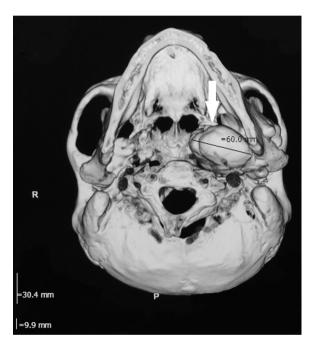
3D CT scan showing a huge hyper dense mass in the pterygoid fossa (arrow).
